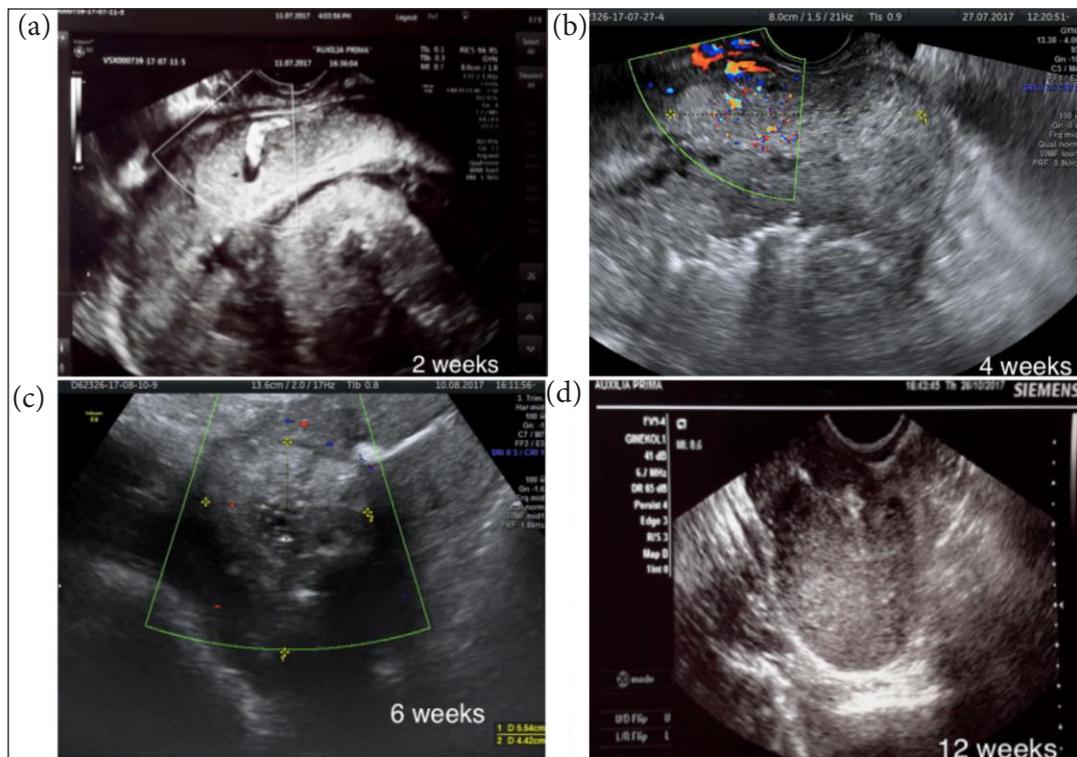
Ultrasound images showing resorption of placenta in case 1. Two weeks after the Caesarean section, the hyperechogenic mass (11 × 11 cm) with rich vascularization (a) was detected; four weeks after operation a decrease in hyperechogenic mass size (6 cm) and vascularization (b); six weeks after, the hyperechogenic mass (5 cm) without vascularization (c); 12 weeks after the operation, a complete resolution of the placenta was diagnosed (d)
